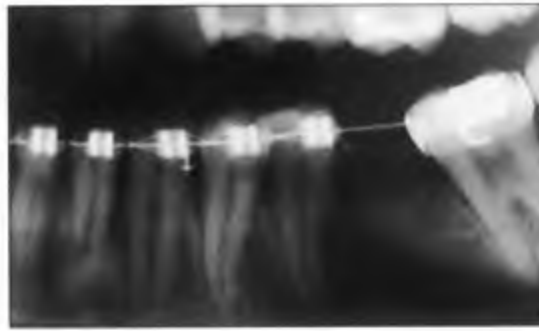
Orthopantomogram (same patient) after removal of implant. The projection shows that hard tissue was not affected, as the exact position of the screw was within the periodontium.
